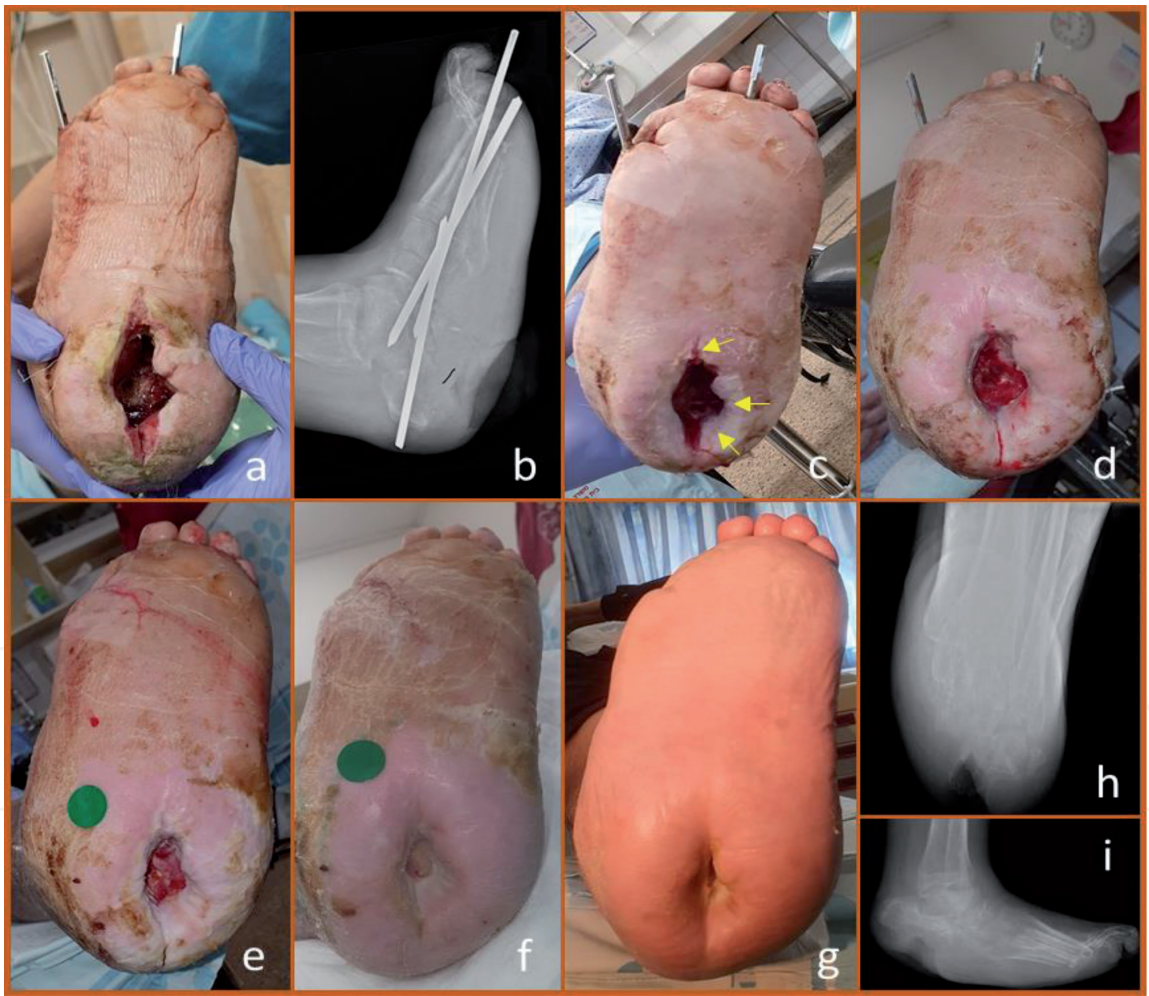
Epithelization of a rocker deformity related plantar deep wound. The patient had resection of infected calcaneal bone with correction and stabilization of ensuing rocker deformity with Steinman pins. COD was applied at surgery. a. one week following surgery the deep calcaneal wound is evident without signs of infection. b. X-ray showing the inserted Steinman pins. The missing plantar calcaneal bone and the deep soft tissue void underneath can be seen. c. Three weeks post-surgery, following the use of the COD, skin began crawling from the side surface into the depth of the wound. Further coverage of the wound granulation tissue with epidermal tissue is seen after 7 weeks (d), 8 weeks (e) and 3.5 months (f) of COD treatment, resulting in 95% complete closure of the wound at 4.5 months (g). h and i. lateral foot and Axial calcaneal X-rays of the foot 4.5 months after surgery. Although large soft tissue void is prominent, it is filled with practically normal looking skin that crawled in. During all this period the foot was treated solely with COD.
